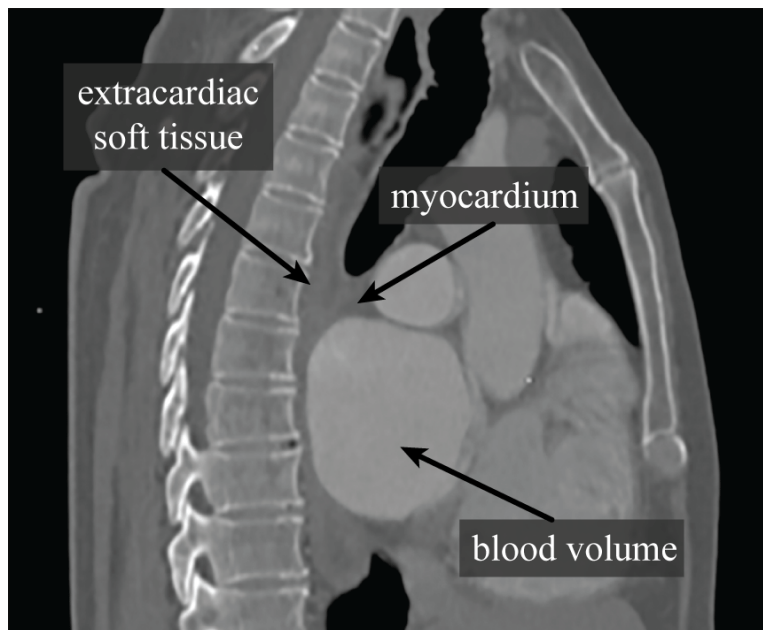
Contrast-enhanced CT scan. Blood volumes have a higher intensity value than surrounding soft tissue. The soft tissue muscle of the heart (myocardium) is indistinguishable from the extracardiac soft tissue.
